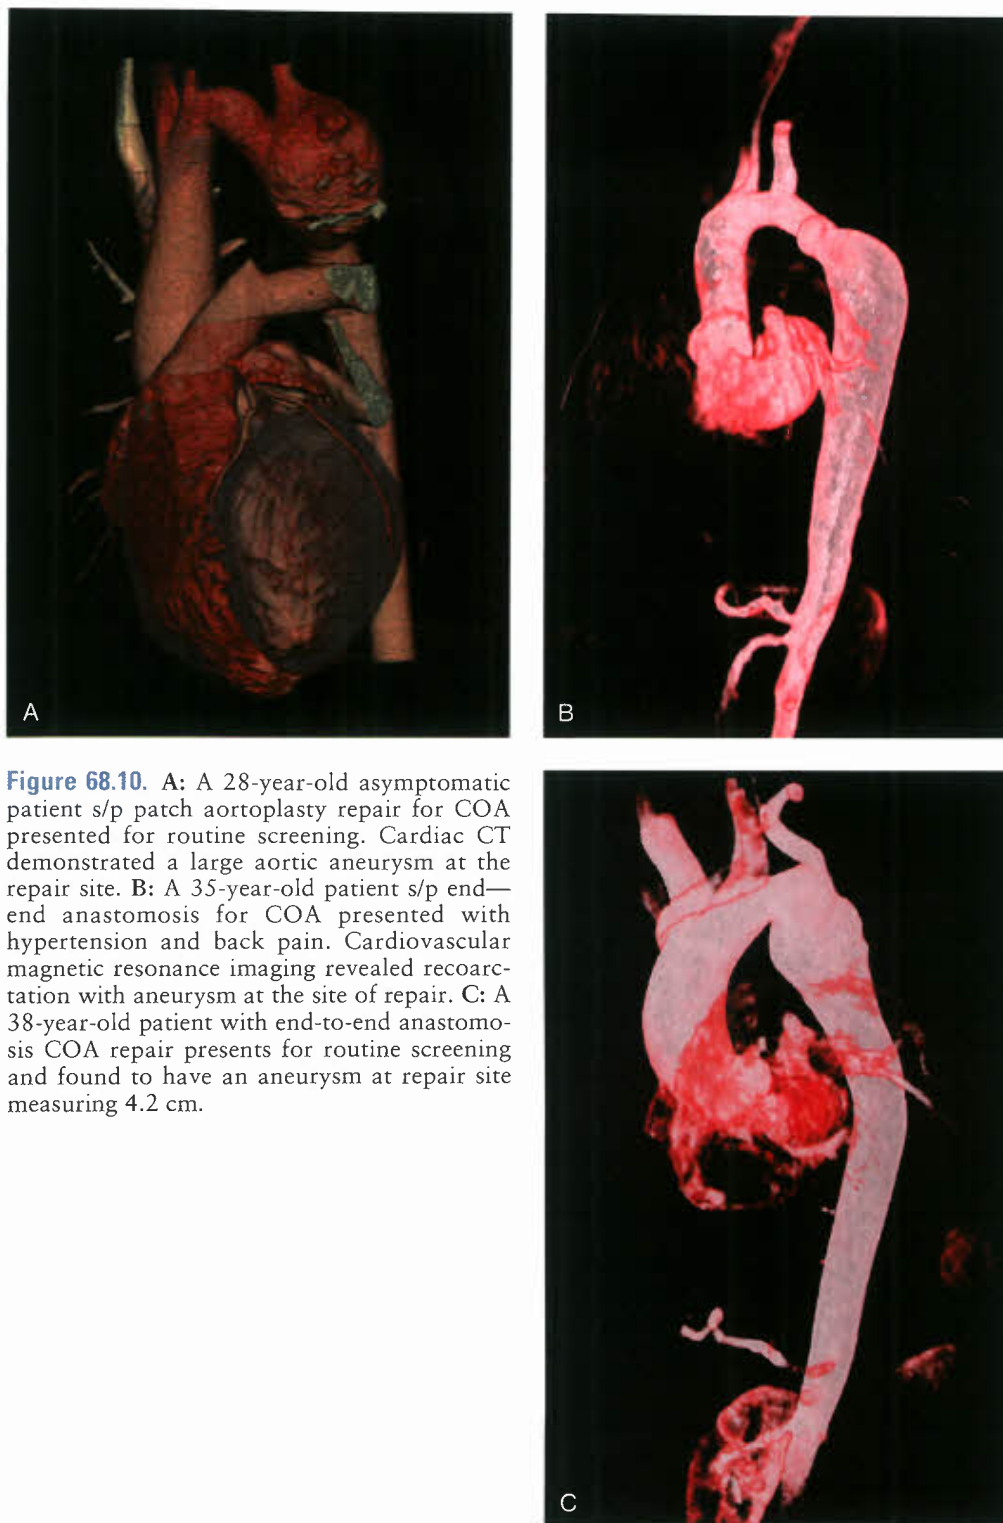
A: A 28-year-old asymptomatic patient s/p patch aortoplasty repair for COA presented for routine screening. Cardiac CT demonstrated a large aortic aneurysm at the repair site. B: A 35-year-old patient s/p end—end anastomosis for COA presented with hypertension and back pain. Cardiovascular magnetic resonance imaging revealed recoarctation with aneurysm at the site of repair. C: A 38-year-old patient with end-to-end anastomosis COA repair presents for routine screening and found to have an aneurysm at repair site measuring 4.2 cm.
